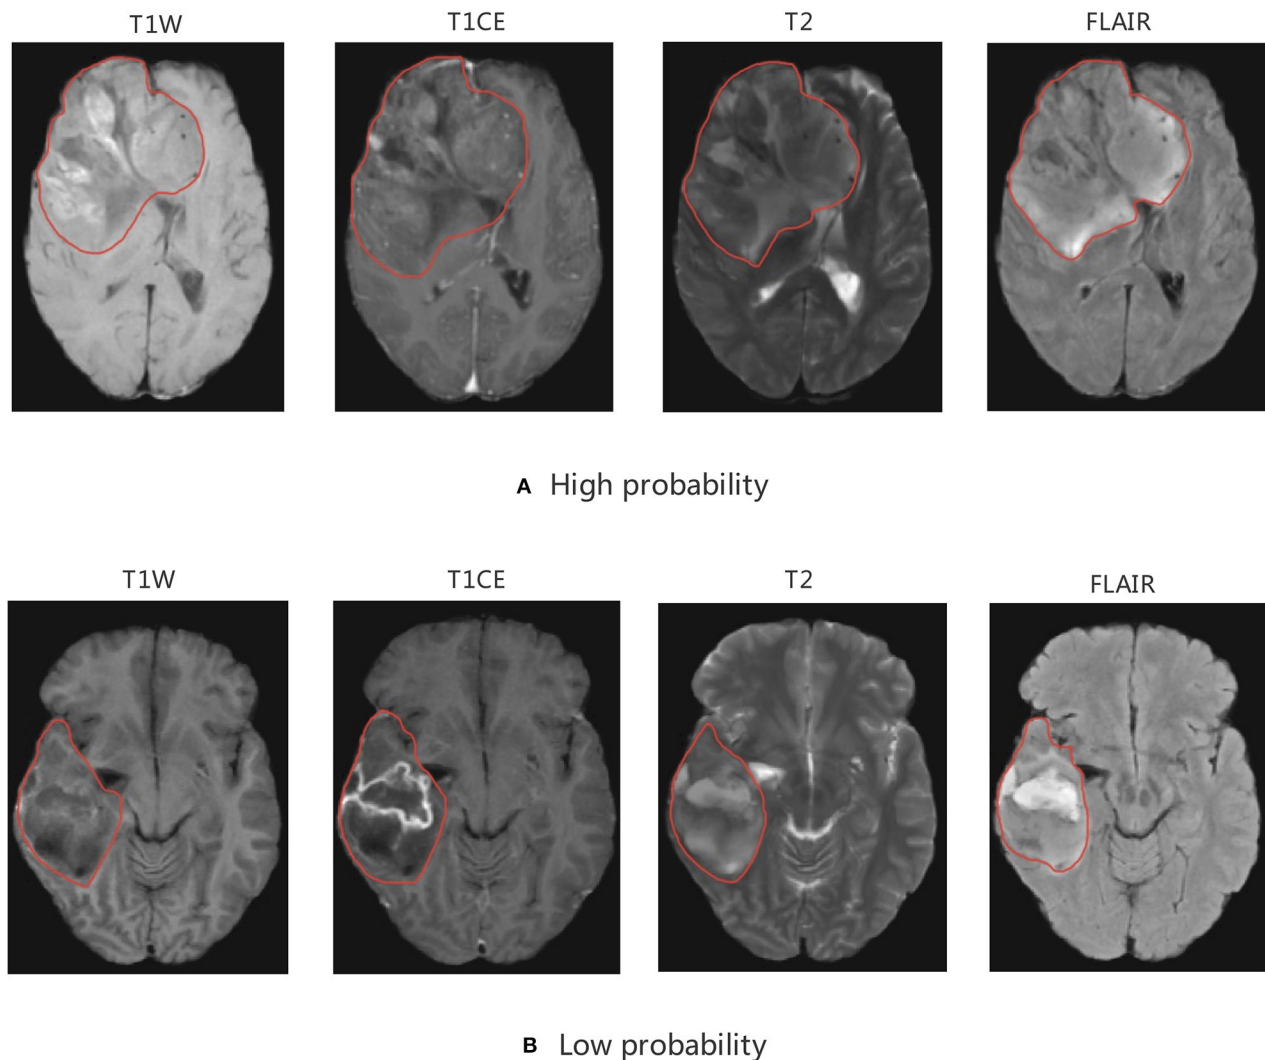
MRI of model-based CIC mutation prediction patients. Image with the (A) high probability of being CIC mutation and (B) low probability of being CIC mutation. The region inside the red line represents glioma region.
